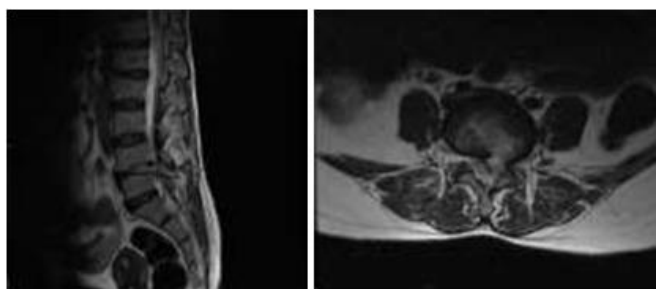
Post op MRI T2 Sagittal and axial images showing decompression status at L4 L5 level.
